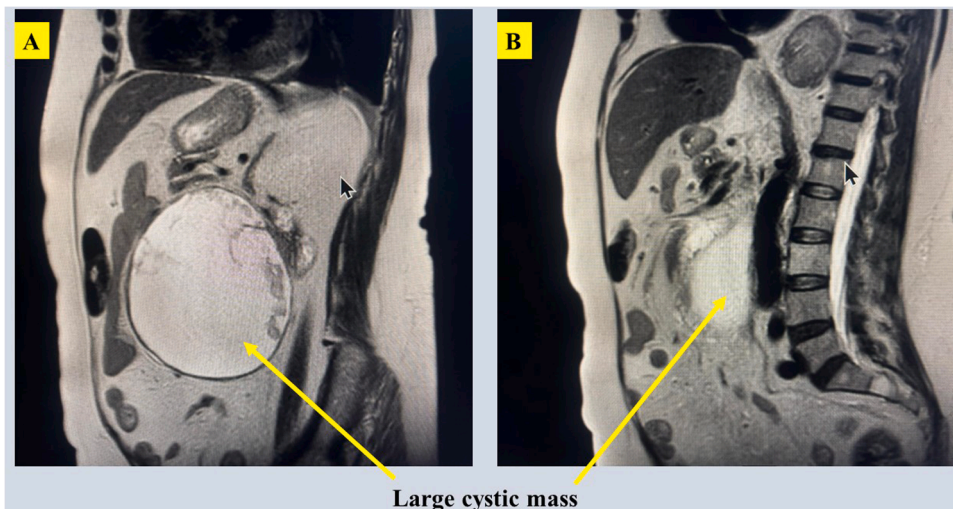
Sagittal MRI view of the Abdominal cyst.
